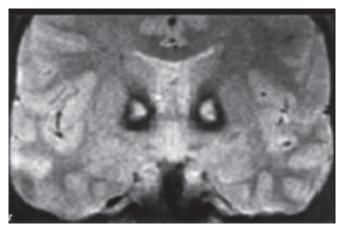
Eye of the tiger sign in coronal magnetic resonance imaging
